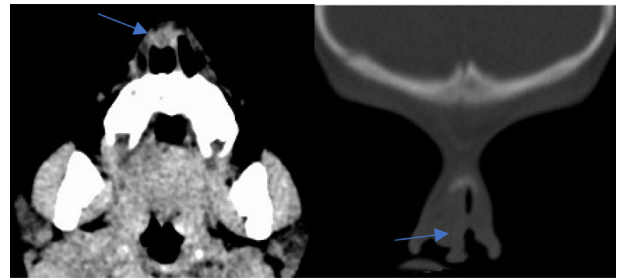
Noncontrast computed tomography scan showing a soft tissue lesion in the anterior right nasal passage.
